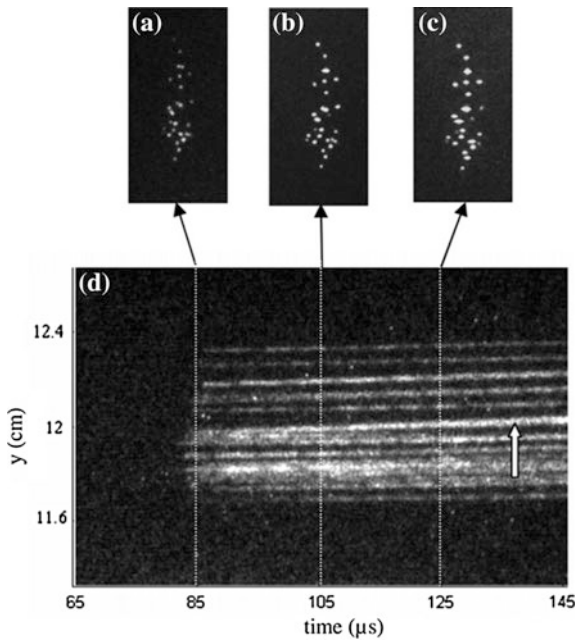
Still images photographed at different times after the onset of ultrasound transmission: a 85 μs , b 105 μs and c 125 μs . Reproduced with permission from Chen et al. © Elsevier
